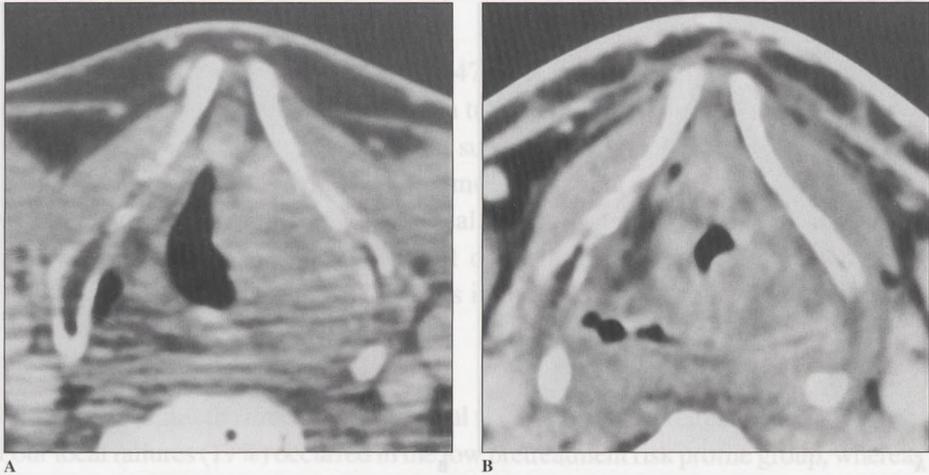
CT images of a patient with a T3 supraglottic carcinoma and a low pretreatment risk profile. (A) Pretreatment CT image: tumor is seen in region of left false cord and paraglottic space. (B) CT image obtained at 2.5 months after radiotherapy. Tumor has regressed, but there is asymmetric obliteration of the fatty tissue at the left side, without obvious focal mass. Post-RT CT-score 2. The patient developed a local failure at 6 months post-RT, which was successfully treated by salvage laryngectomy.
